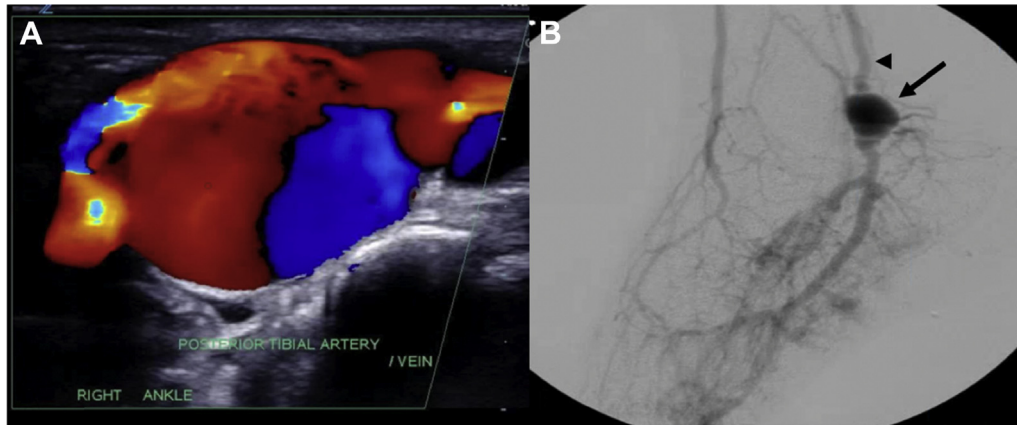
A, Arterial duplex ultrasound image showing aneurysmal dilation of the posterior tibial artery. B, Angiogram demonstrating patent posterior tibial artery (*arrowhead*) and the posterior tibial aneurysm (*arrow*).
